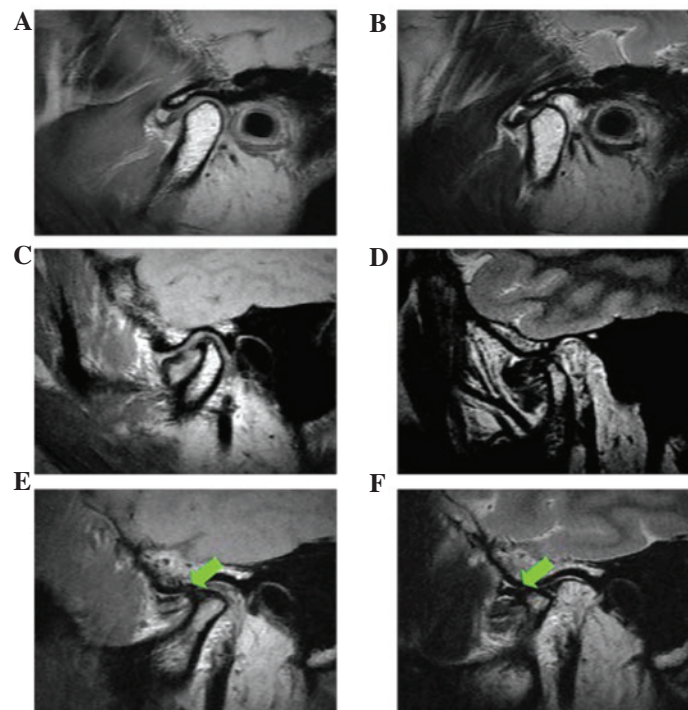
Magnetic resonance imaging (MRI) ofttemporomandibular joint osteoarthritis (TMJ OA) combined with disc displacement (DD) is shown. (A and B) showed early TMJ OA combined with DD; (C) and (D) showed intermediate TMJ OA combined DD; (E and F) showed late TMJ OA combined with DD; (A, C and E) closed position; (B, D and F) open position. Green arrow, disc perforation.
